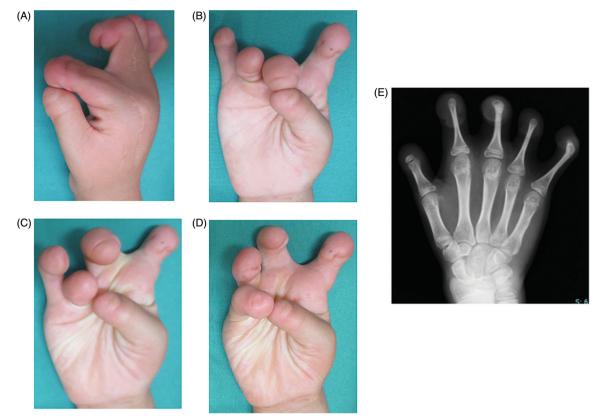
Postoperative f hand function and phalangeal length more than 10 years. At the latest evaluation, hand functions were preserved (A–D), and there was no significant relative shortening of the lengthened phalanges on the radiographic findings (E).
